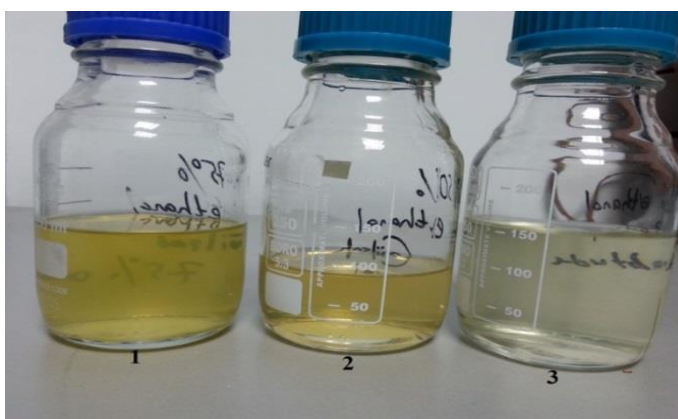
Alcohol extracts in ultrasonic treated samples
